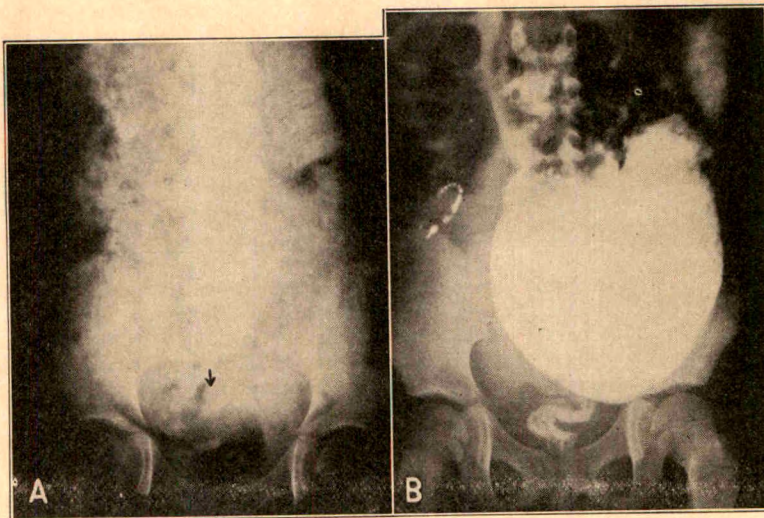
(case 21).—*A*, roentgenogram showing enormously dilated descending colon and upper portion of the sigmoid colon in a 9 year old boy. The arrow indicates the normal lower segment of sigmoid colon and the normal rectum, visualized by air contrast. Additional examinations demonstrated that the proximal segments of the colon were also dilated and at times impacted. *B*, roentgenogram of the same patient showing the megacolon after repeated enemas given during nine days. The impaction has been partly washed out. The normal lower portion of sigmoid colon and rectum have not dilated.
